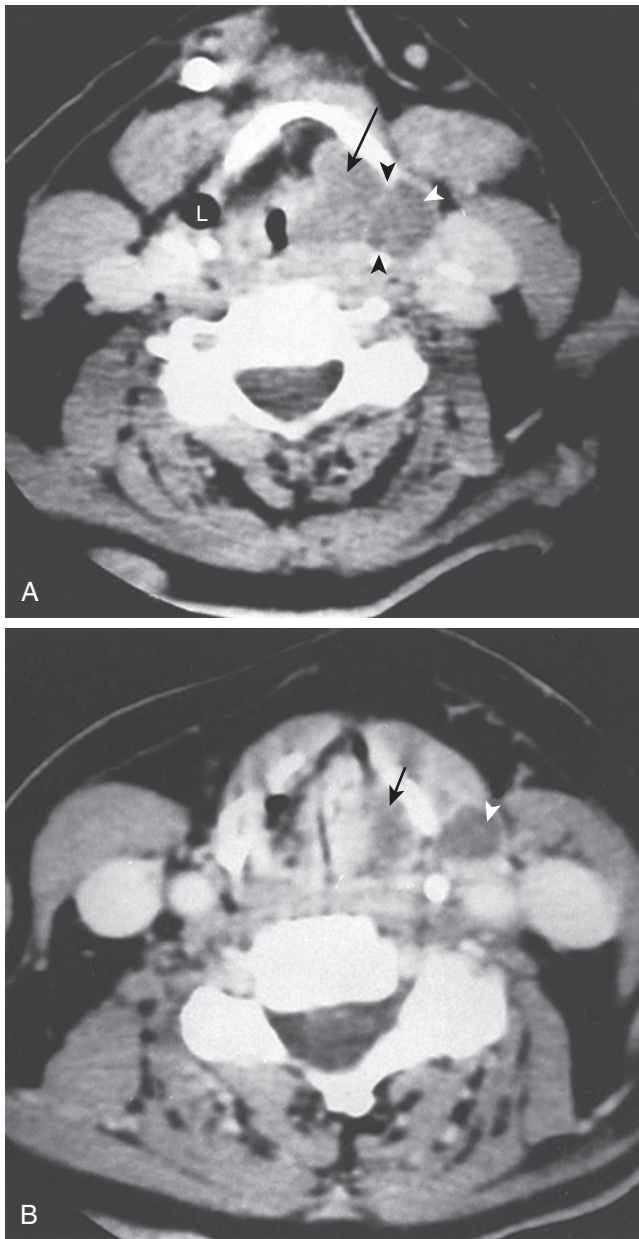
Axial CT of a laryngocele (saccular cyst).
